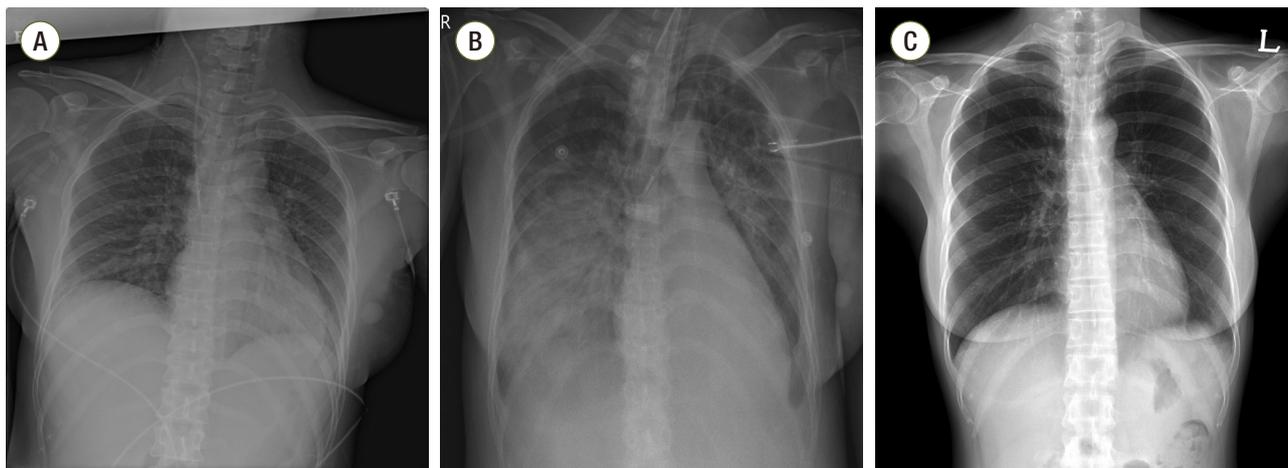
(A) Chest radiograph on arriving at emergency department shows no evidence of pulmonary infiltration. (B) Chest radiograph on fourth hospital day shows that bilateral dense consolidation and intubated state. (C) On discharge, chest radiograph shows bilateral consolidation is resolved.
